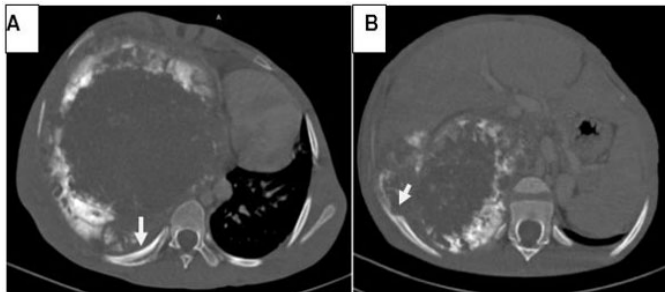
Thoracic CT (bone window): axial sections revealing a plurilamellar periosteal reaction of the posterior arch of K9 (A) and focal lysis of the middle arch of K10 (B).
